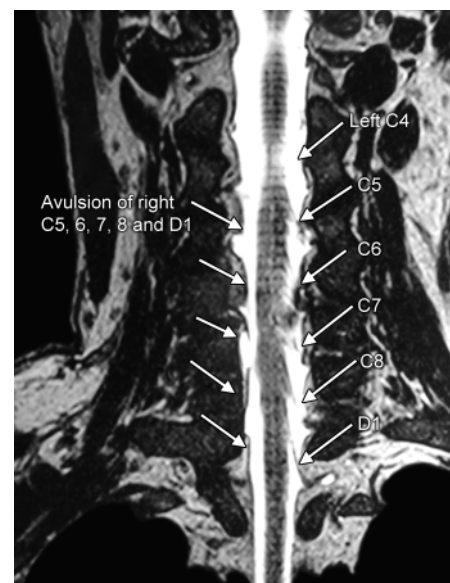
MRI showing root avulsion on the right side
